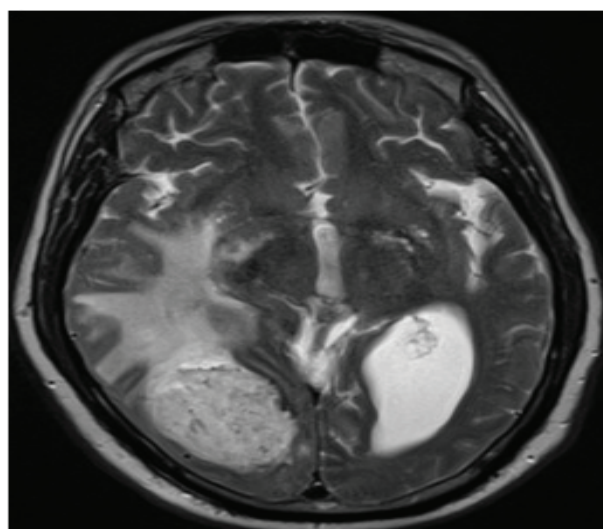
MRI: Dural lesion appearing hypointense on T1 weighted images with no calcification/ hyperostosis. department with complaints of intermittent seizures and headache since a year. Routine biochemical parameters were within normal limits. MRI done
